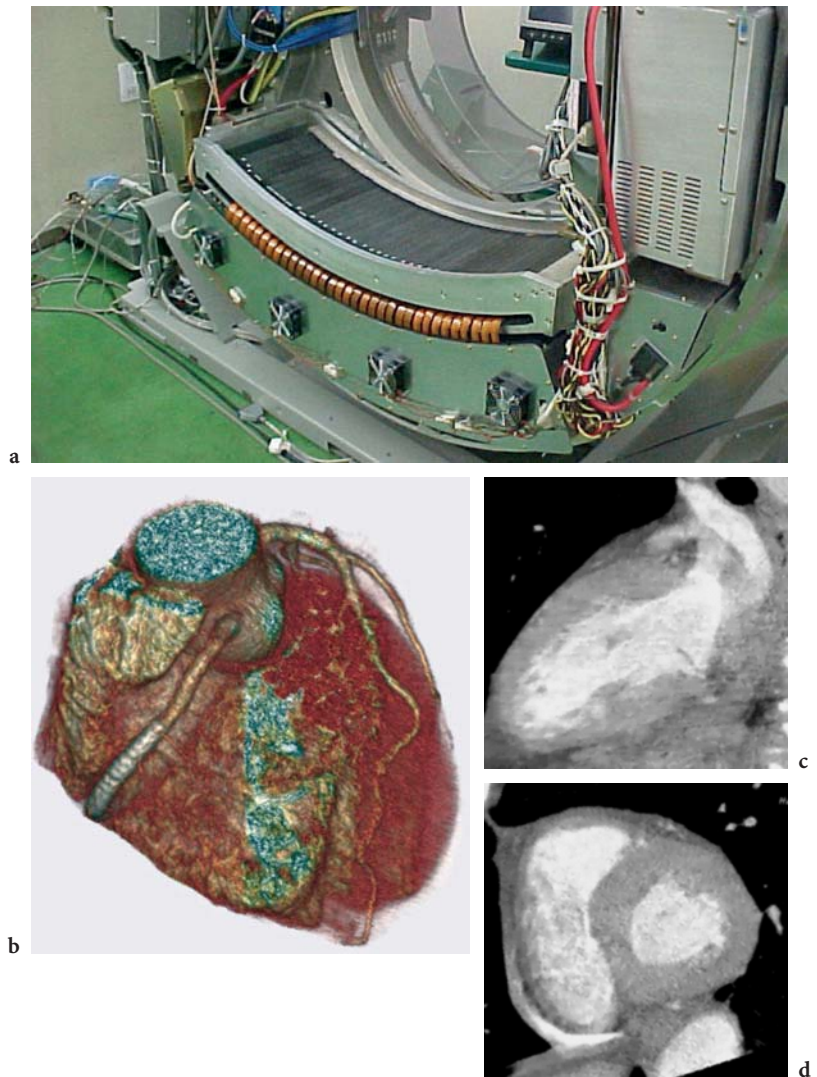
The principle of area-detector CT and preliminary, experimental, in-vivo patient results using a prototype with 256×0.5 -mm slices and 0.5-s rotation time. a The area-detector prototype is mounted in a conventional multi-slice CT gantry system and provides volume coverage up to 12 cm. b A 4-dimensional data set of the heart and coronary arteries can be acquired from scans with one single rotation without table-feed. MPR display of the same data set allows for reconstruction of the left ventricle in the long (c) and short (d) axes. (Data courtesy of Ehime University, Japan)
